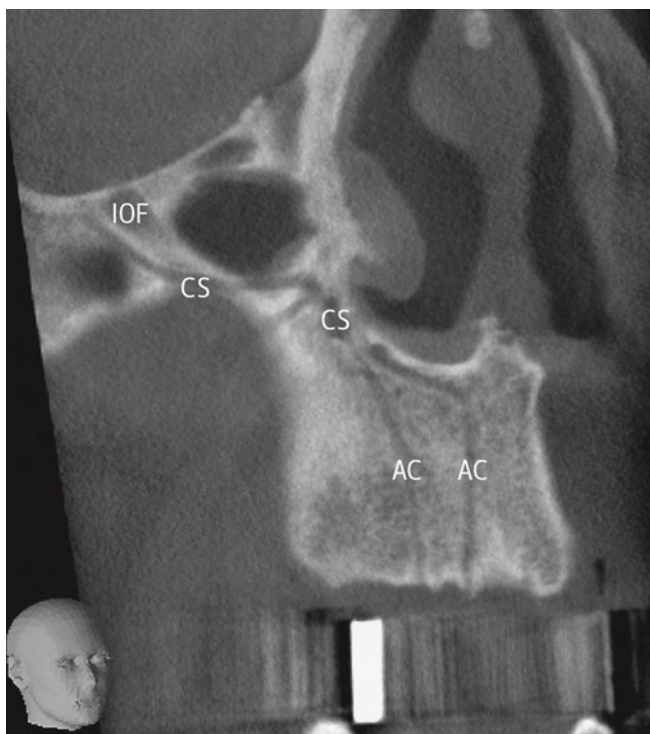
Reformatted (oblique) CBCT plane through right midface/anterior maxilla of a 62-year old male showing CS and AC.
